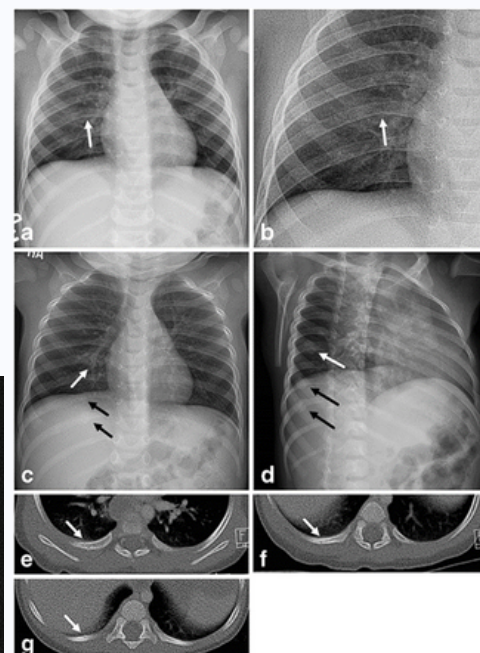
Image of 2 month old boy with fall and bruises found to be a victim of child abuse. a, b Anteroposterior (AP) showing a possible acute, nondisplaced right 7th posterior rib fracture rib fracture (arrow). c, d AP and oblique views from the follow up radiographic survey performed 22 days later showing subacute healing fractures of right 7th (white arrows), 9th and 10th (black arrow) posterior ribs. e, g Ct examination of abdomen, chest and pelvis performed the same day as initial X-ray survey demonstrates right 7th (e), ninth (f) and tenth (g) posterior rib fracture (arrows) which were occult on the initial radiography
